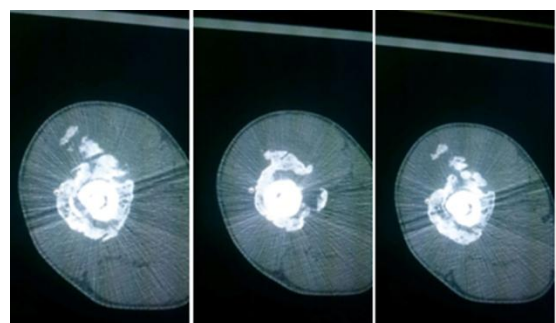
CT scan (axial slices): hypodense area with crown-shaped calcifications with clear centers, separated from the bone
